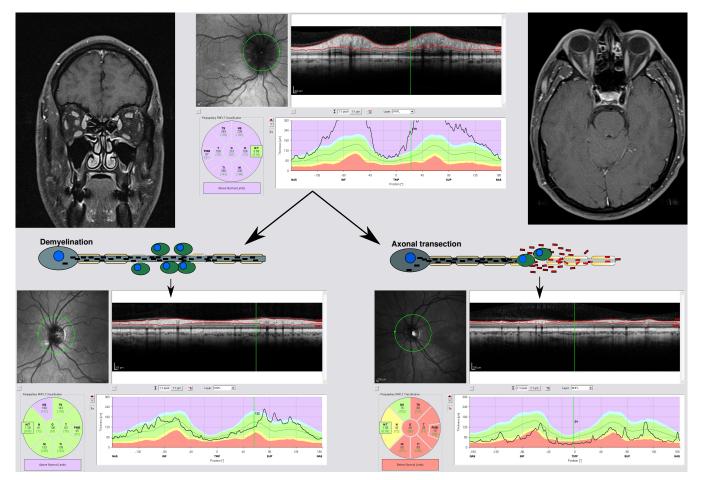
A holistic model combining the strength of biomarkers suited for diagnosis (whole brain and spinal cord MRI) of the acute phase of neurodegeneration (e.g. body fluid neurofilament levels) with those more reliable during the later phase of neurodegeneration related atrophy measures (retinal OCT). A fundamental problem of imaging techniques is that any inflammation related oedema in the acute phase will mask neurodegeneration-related atrophy. Likewise, body fluid biomarkers such as neurofilaments will predominantly be released from disintegrating axons/neurons during the acute phase and only to a smaller degree during the "burnt out phase". A logical combination of these two distinct methodological approaches would be to have them integrated in longitudinal studies on neurodegeneration in MS.
